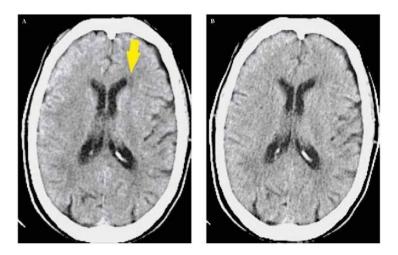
standard (A) and low dose (B) CT scans. Chronic lacunar infarct (yellow arrow): the lesion is well seen only with the standard technique (A) (11).
